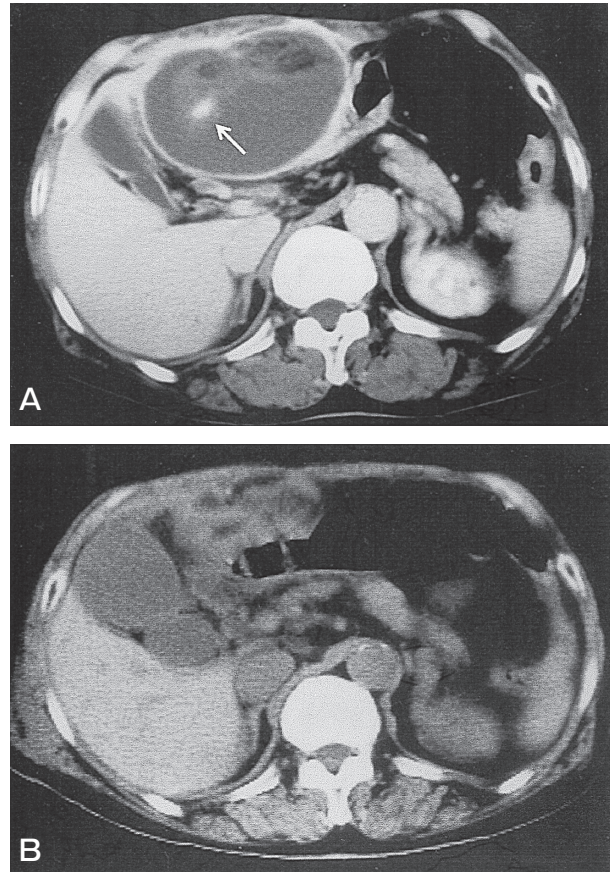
A, Computed tomography shows a large abscess, $9 \times 6\text{cm}$, at the round ligament of the liver. The existence of the umbilical vein (arrow) which runs inside the abscess and is connected to the left branch of the portal vein confirmed that the abscess was formed inside the round ligament; B, An identical CT view during the patient's first visit showed no abscess formation.
